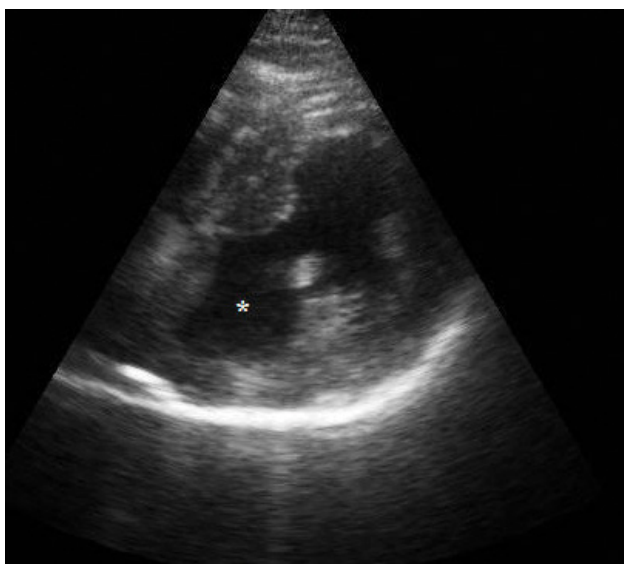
Parasternal short-axis view shows a large echo-free space behind the inferior wall that communicates with the left ventricle through a narrow neck
